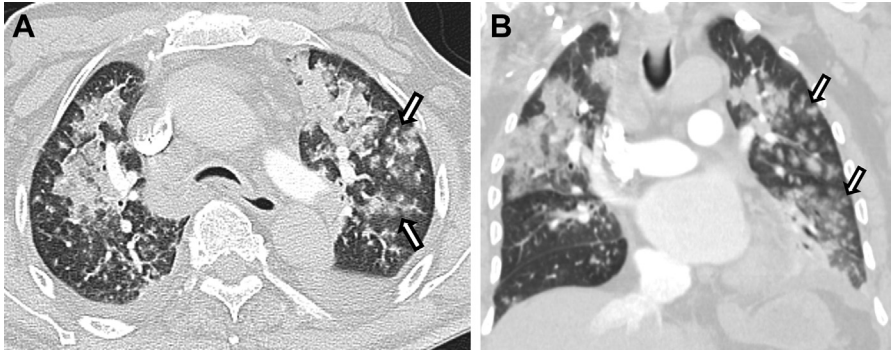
Human metapneumovirus in a 63-year-old man. (A) Axial and (B) coronal chest CT images demonstrate bilateral peribronchovascular consolidation and ground-glass opacities indicative of bronchopneumonia. Centrilobular nodules (*arrows*) are also consistent with airway-centric disease. Incidental note of probable tracheomalacia on (A).
